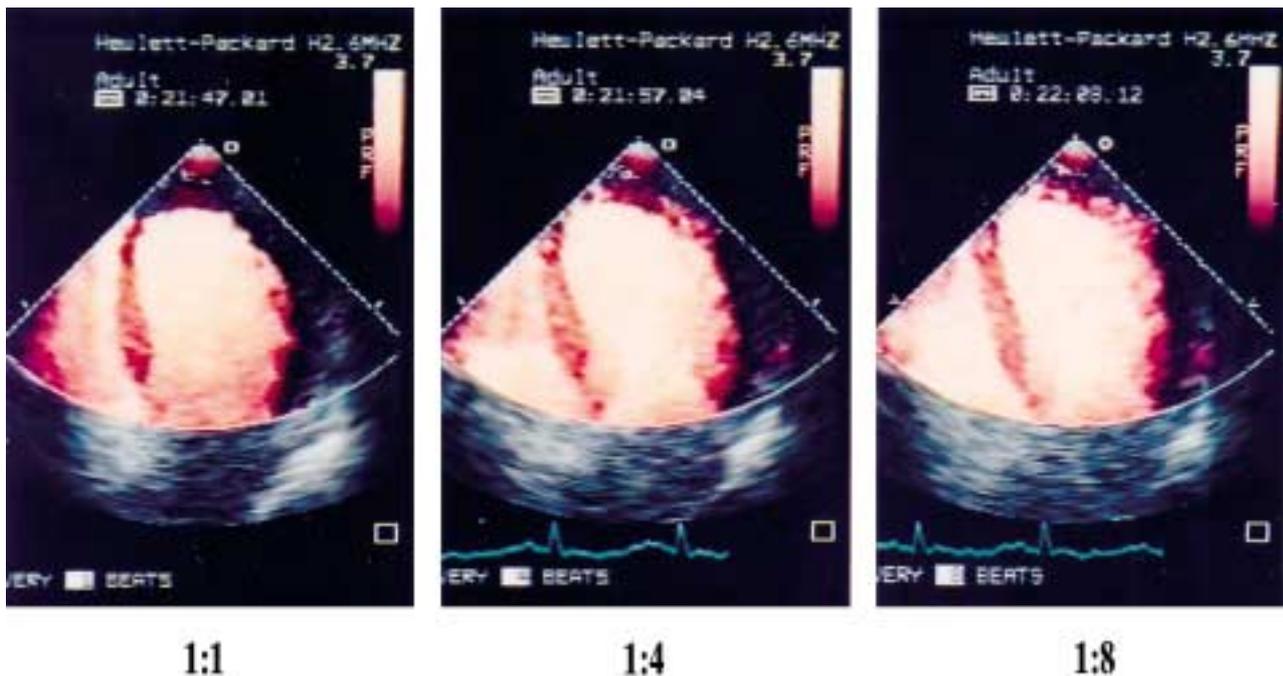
Apical 4-chamber view from patient with acute myocardial infarction with absent contrast opacification in the apex at short triggering intervals, but homogenous opacification with delayed triggering.
